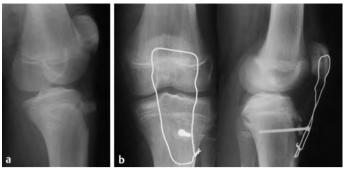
b Bony patellar tendon avulsion of the tibial tuberosity. a Radiograph. b Radiograph after reattachment with screw; backup with McLaughlin loop.
